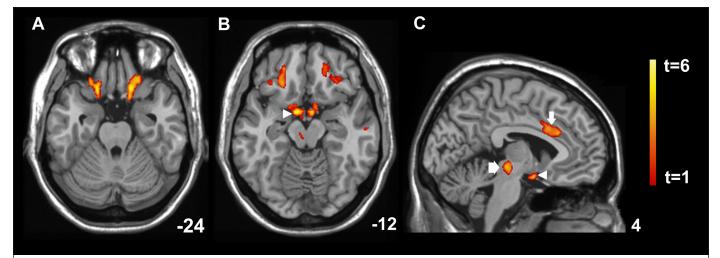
SPM (t) axial intensity projection maps rendered onto a stereotactically normalized MRI scan, showing areas of significant increases of MD values (color code, yellow to orange) in a cohort of patients with narcolepsy-cataplexy versus healthy control subjects. The number at the bottom right corner of each MRI scan corresponds to the z coordinate (A and B) and x coordinate (C) in MNI space. Fronto-orbital cortex (A), hypothalamus (B and C, arrowhead), cingulate (C, small arrow), and ventral tegmental area (C, large arrow) are identified.
